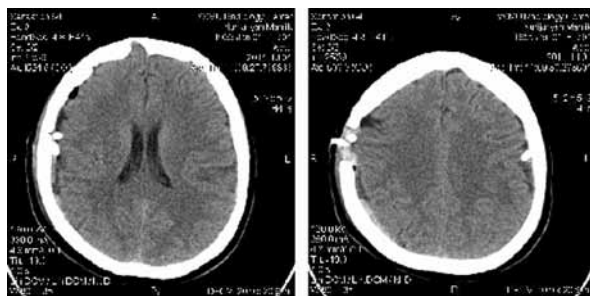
CT of the brain after the operation
